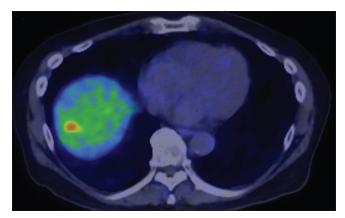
Fused axial image of the liver lesion seen on gallium-68 prostate-specific membrane antigen positron emission tomography/ computed tomography
